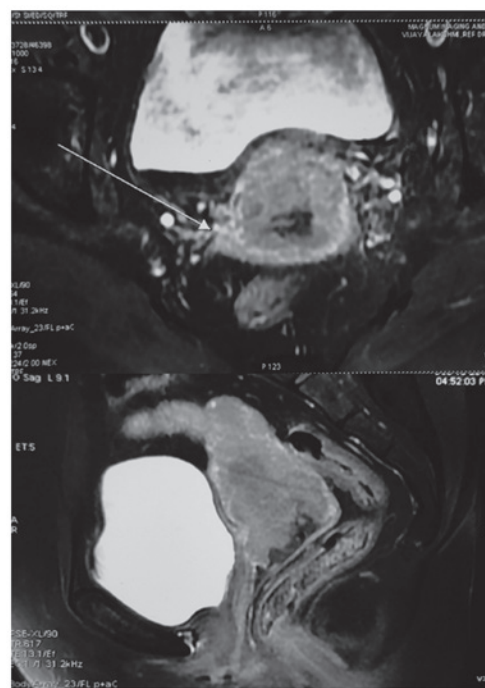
Prechemotherapy MRI pelvis with contrast: Growth in the uterine cervix infiltrating the lower 3rd of myometrium and bilateral parametrium; with enlarged bilateral internal iliac nodes (arrow).
